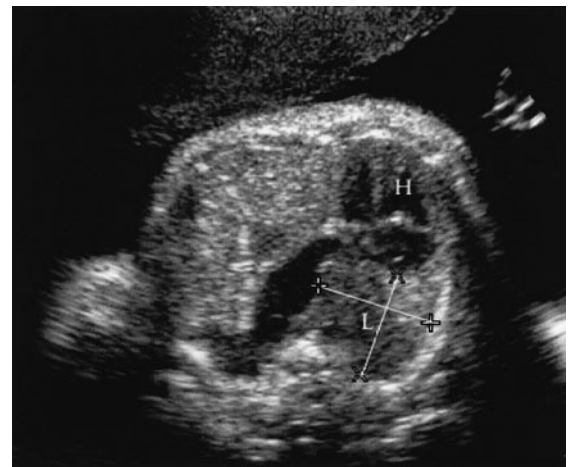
Ultrasound of congenital diaphragmatic hernia at the level of the transverse four-chamber view of the heart (H) showing measurements used for LHR calculation on the right lung (L).
